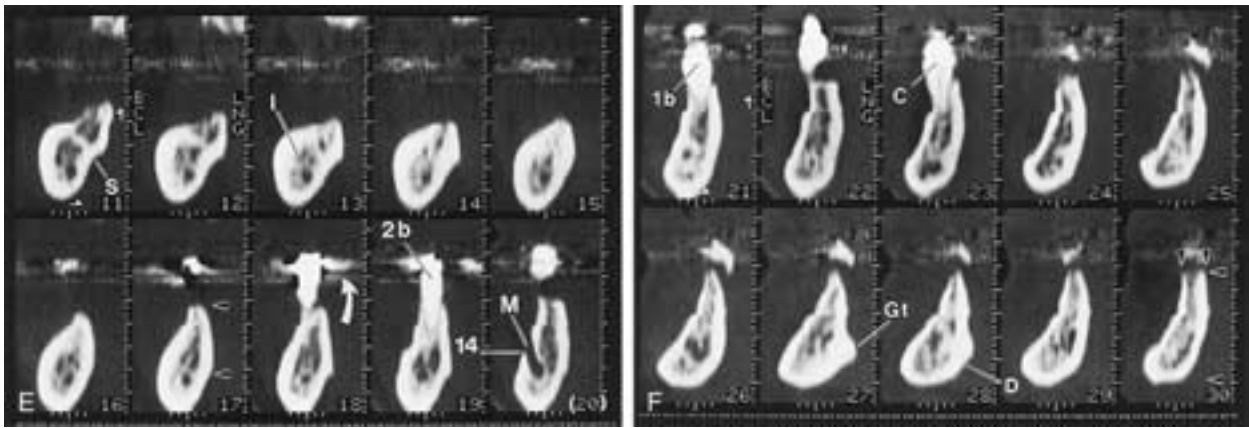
Continued.* Images 11 through 20 (E) are more anterior. Images 21 through 30 (F) extend to the midline. The images of the left half of the mandible are not shown. Arrowheads in image 17 (E) indicate that the height of the mandible distal to the mental foramen is measured from the top of the alveolar process to the top of the mandibular canal, and mesial to the foramen it is measured from the top of the alveolar process to the bottom of the mandible (arrowheads in F, image 30). Measurement of the width is also demonstrated in image 30 (F). *mm* at the bottom of D indicates the millimeter scale. Note how streak artifact from dental restoration (curved arrow in E) does not degrade visualization of the bone. A indicates alveolar process; C, cuspid; Cp, coronoid process; D, digastric fossa; Gt, genial tubercle; I, inferior alveolar canal; M, mental foramen; Mf, mandibular foramen; Mg, mylohyoid groove; Ml, mylohyoid line; O, oblique line; Rf, retromolar fossa; Rt, retromolar triangle; S, submandibular fossa; Sl, sublingual fossa; T, temporal crest; 1b, first bicuspid; and 2b, second bicuspid. (From Abrahams JJ. Anatomy of the jaw revisited with a dental CT software program: pictorial essay. *AJNR* 1993;14:979–990.)
